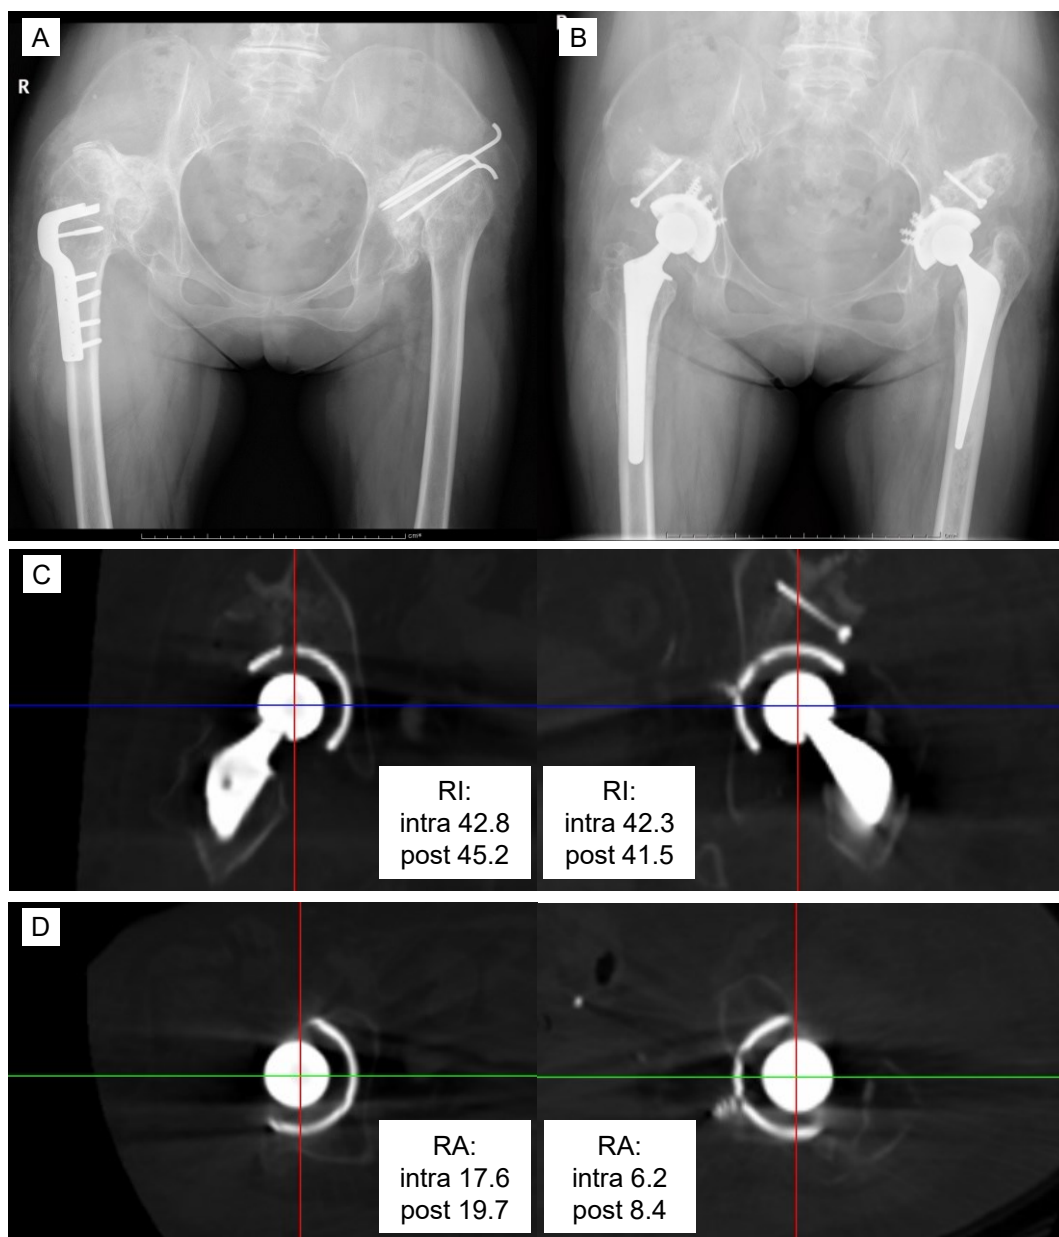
(A) 57 years-old female with bilateral acetabular dysplasia. She had previously received right femoral valgus osteotomy and left hip arthrodesis. (B) We performed bilateral THA using CT-based 2D-3D matched navigation. (C) (D) Postoperative CT measurement of cup position. Radiographic inclination (RI), radiographic anteversion (RA), intraoperative record (intra), and postoperative measurement (post) are shown. There is little difference between intraoperative record and postoperative measurement.
